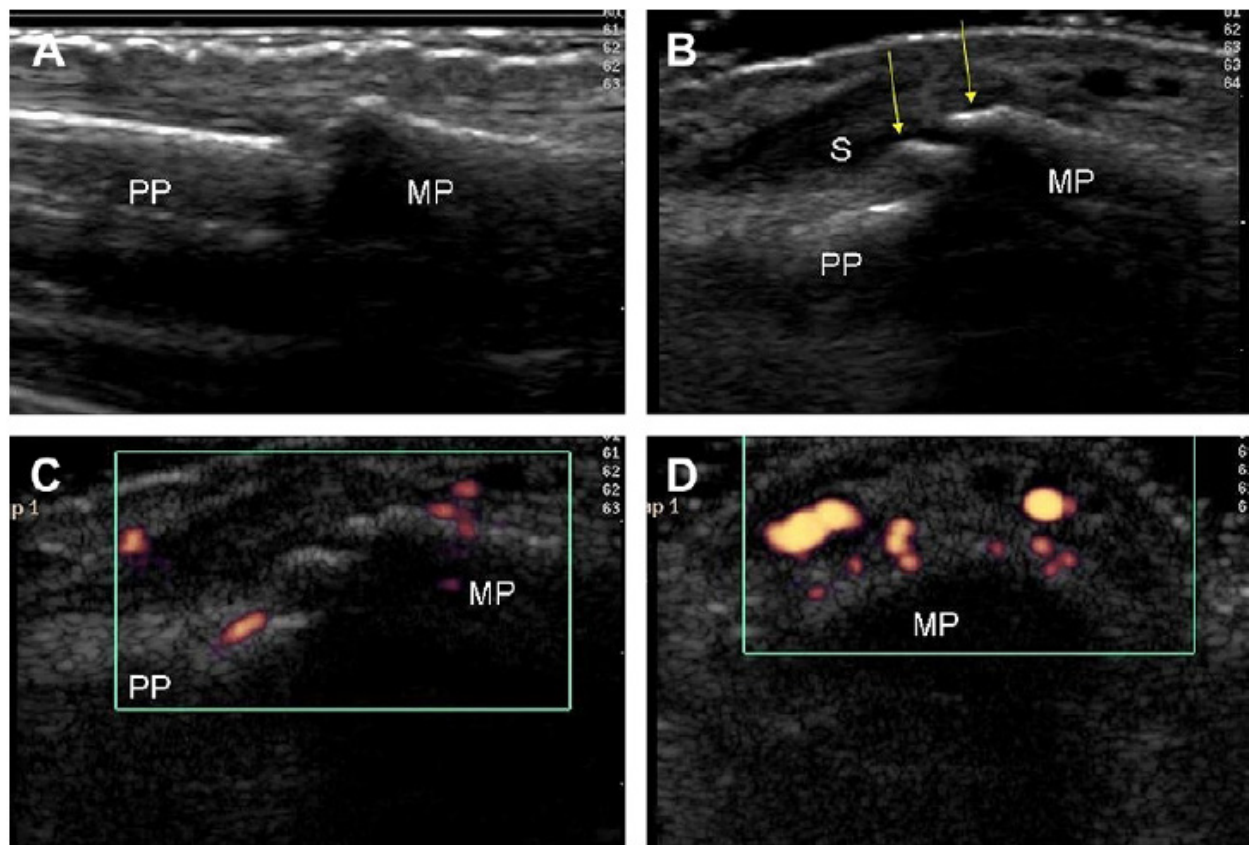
OA of the proximal interphalangeal (PIP) joint. (A) Dorsal longitudinal ultrasound image of a normal PIP joint, with smooth cortical outlines. (B) Dorsal longitudinal ultrasound scan of osteoarthritic PIP joint demonstrates proximal and distal dorsal osteophytes (yellow arrows) and synovial hypertrophy (dark area indicated by an S). Dorsal longitudinal (C) and transverse (D) ultrasound scans of the PIP joint shown in B, with power Doppler function added, demonstrate Doppler signal within the hypoechoic synovial hypertrophy. PP, proximal phalanx; MP, middle phalanx.
